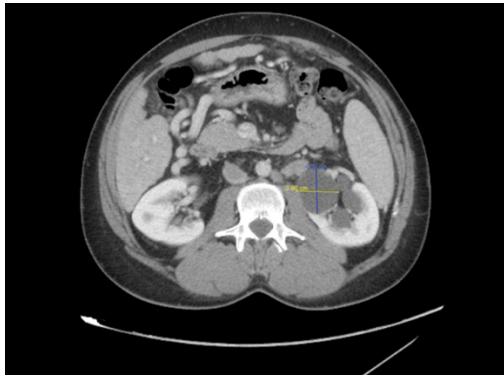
CT scan of the abdomen and pelvis with IV contrast, axial cut, showing interval development of left moderate hydronephrosis, grade 2-3, with no apparent obstructive causes seen. The CT shows that the left ureter is not dilated in addition to interval increase in the size of a previously noted right PPC.
